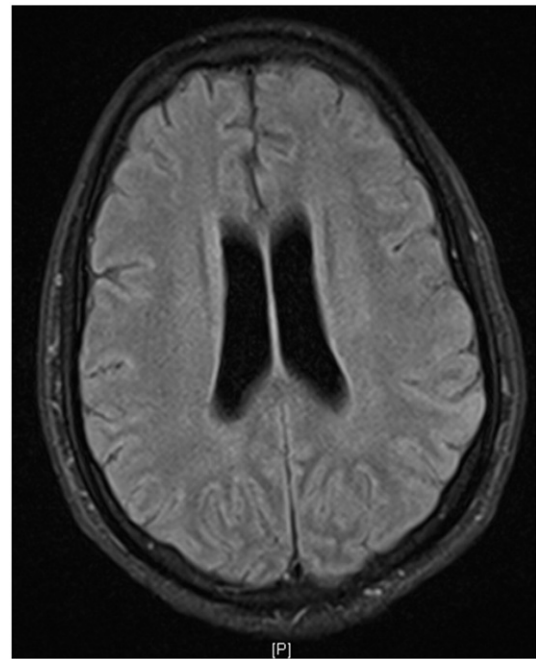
Repeat axial brain MRI scan at 1 month.
